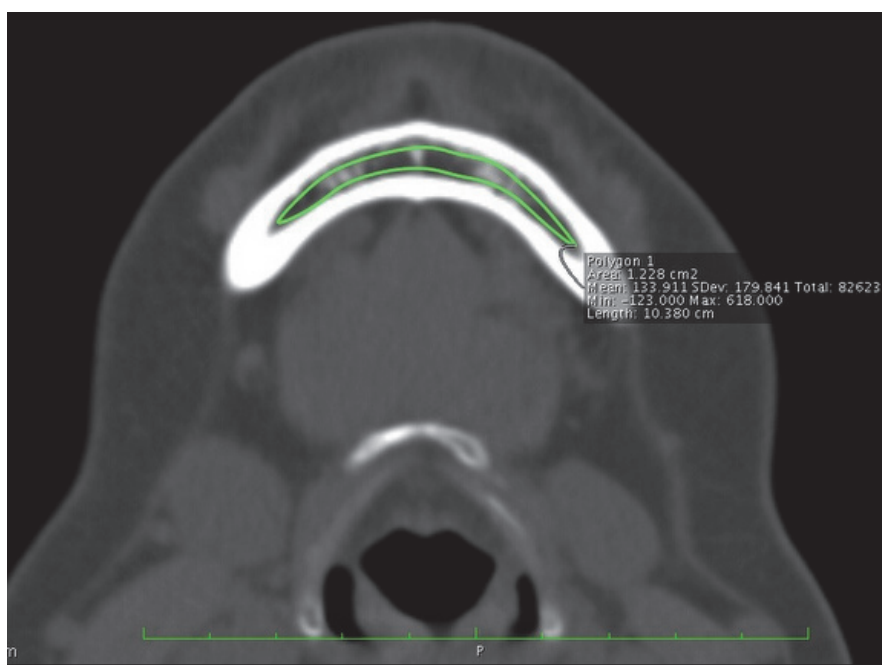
Axial mandible CT slice of 36-year old woman shows nonosteoporotic mandible bone density measurement in Hounsfield Unit (mean: 133 HU).
